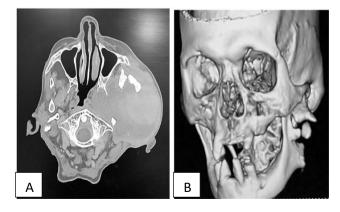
CT-scan showing (A) active hematoma and (B) 3D Ct-scan showing the fracture of left ramus of mandible.
